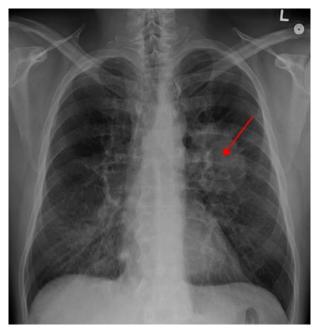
A Chest x-ray displaying a tumour in the Lung (Latimer & Mott, 2015).
